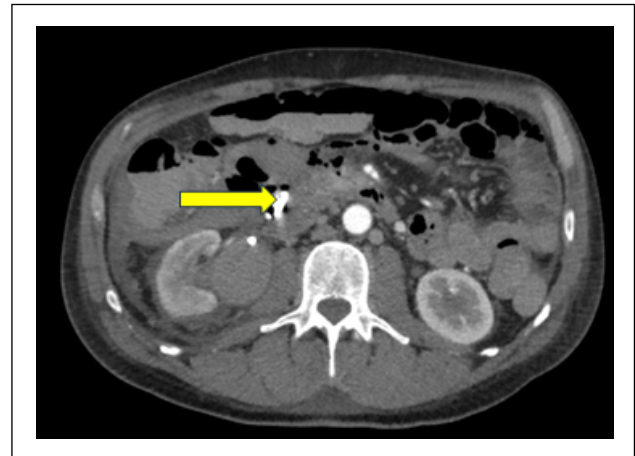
CT scan and hemodynamic instability: active bleeding and hemoperitoneum.
